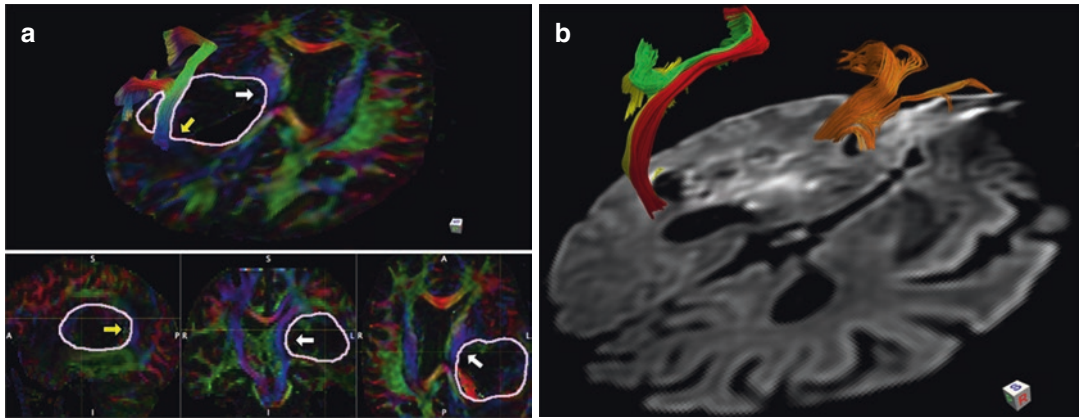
(a) Sixty-five years-old right-handed female with recent onset of severe comprehensive aphasia. MRI showed a large enhancing mass deep seated in the left posterior temporal lobe. DEC maps with tractography showed that the mass dislocated anteriorly and medially the left CST (white arrows) and posteriorly the left AF (yellow arrow). In the upper box MR tractography of the direct segment of the AF with DEC streamlines. In the lower
